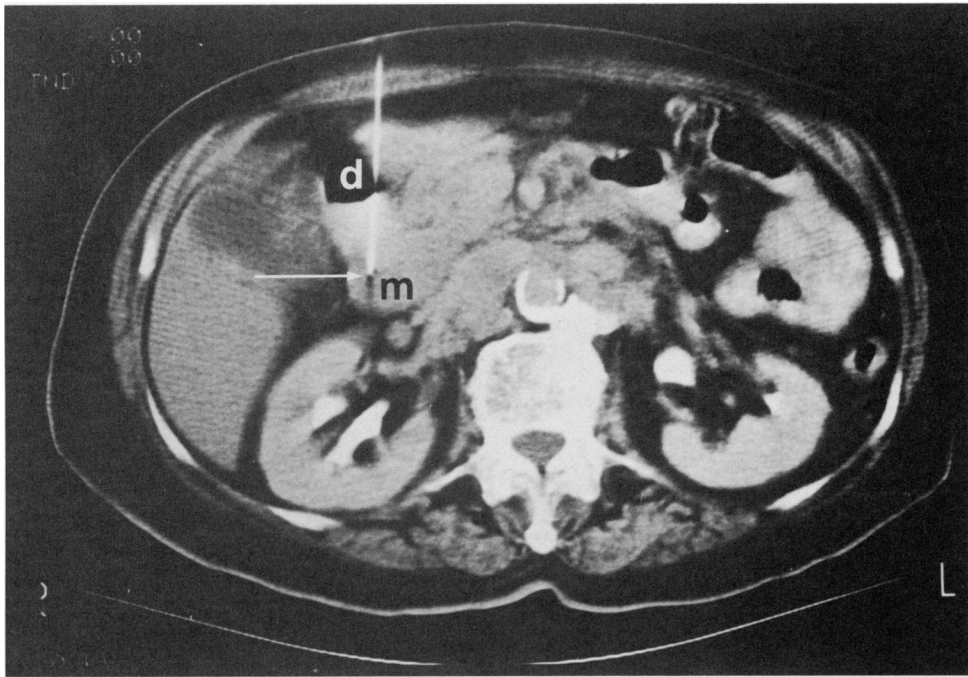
CT scan demonstrating needle passing through duodenum (d) into pancreatic head mass (m). The biopsy revealed adenocarcinoma in the pancreas. The needle tip within the mass is demonstrated by the arrow.
